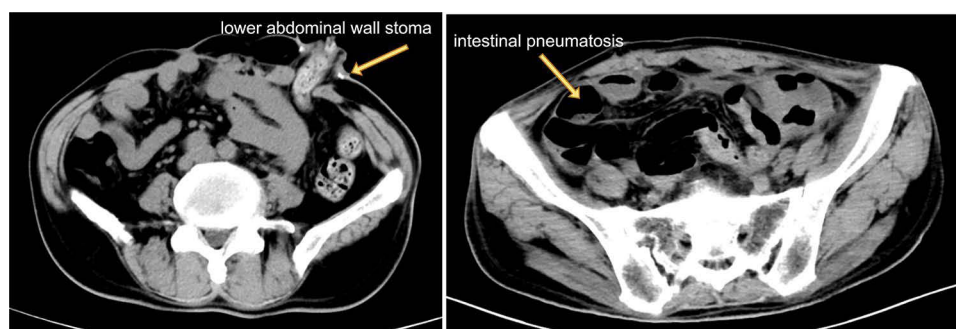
Abdominal CT image of the patient after the operation. The left arrow indicates the left lower abdominal wall stoma. The right arrow indicates intestinal pneumatosis in the right lower abdomen. Additional findings include postoperative exudate in the surgical area, stranding of the fat planes, and a small amount of pelvic fluid.
